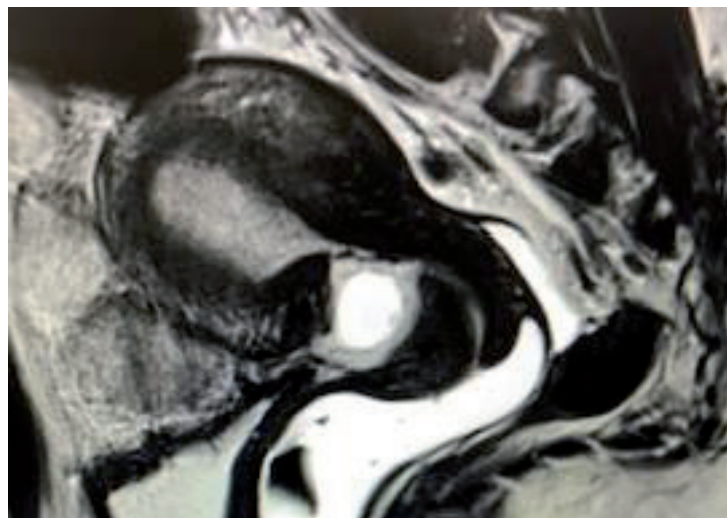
MRI of the uterus demonstrating an empty uterus, an empty cervical canal, the gestational sac being located in the anterior part of the isthmic portion of the uterus with a diminished myometrial layer, and a discontinuity in the anterior wall of the uterus.
